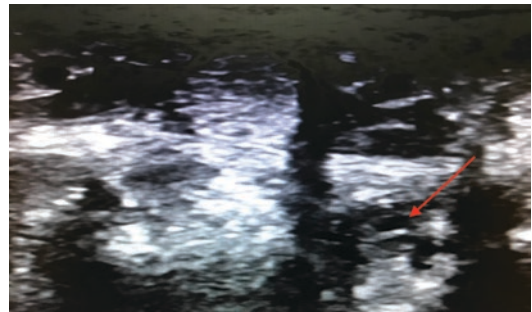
Ultrasound of the lumbrical rupture in the same patient
